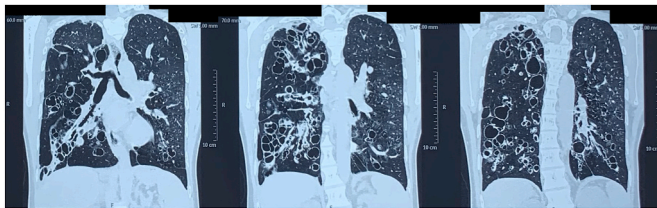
Thoracic HRCT showed cystic type dilatation and thickening of the superior, middle, inferior of the right lung's bronchial branches, and inferior bronchial branches of the left lung, and fibrosis in the anterobasal segment of the right inferior lobe.
